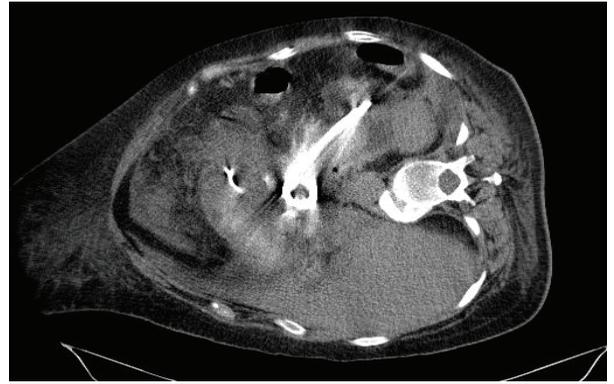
CT-guided percutaneous insertion of a drainage
